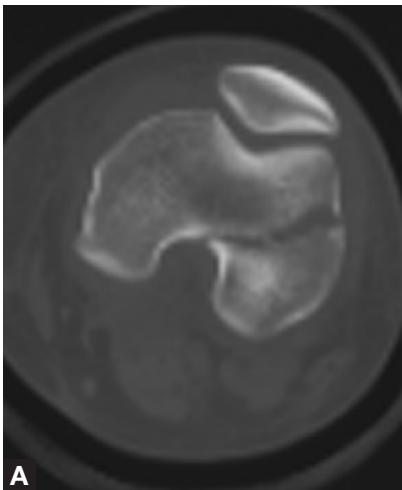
Case 2—Axial (A) and sagittal (B) computed tomography (CT) sections show displaced coronal plane Salter III fracture of the right lateral femoral condyle in a 15-year-old boy.
